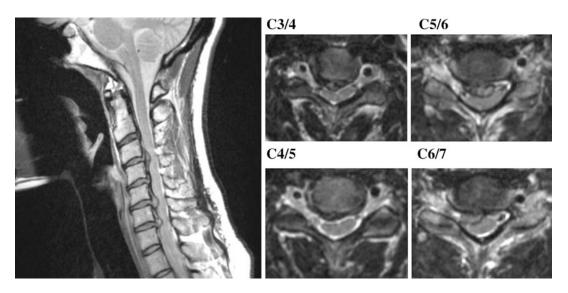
Case presentation: MRI of a 45-year-old woman with progressive CSM reveals a multilevel degenerative process with disc herniations from C3/C4 to C6/C7 causing spinal cord compression with T2 signal
